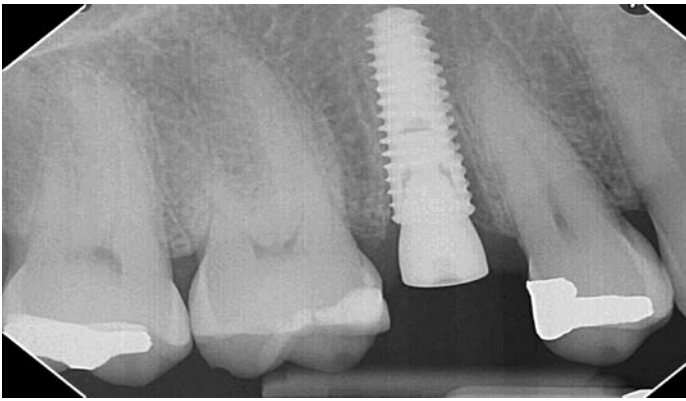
Intraoral Periapical view
